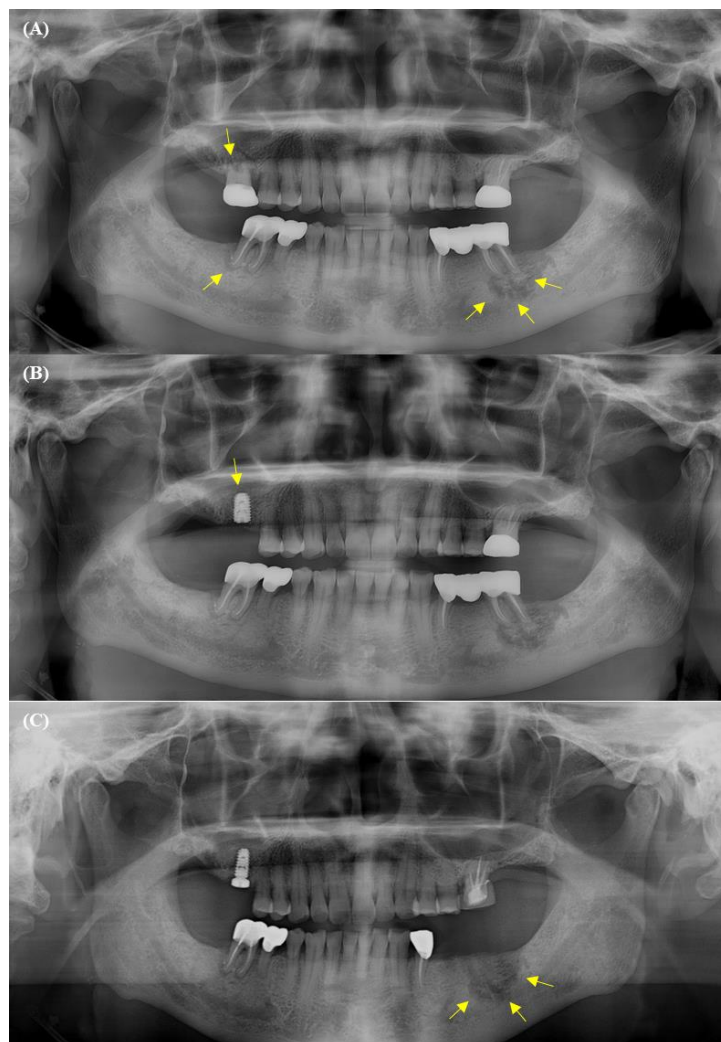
MRONJ case 2; (A) Panoramic radiograph taken at the initial visit, showing periodontitis in the right posterior maxillary region and MRONJ lesions in the right posterior maxilla, left posterior mandible, and right posterior mandible. (B) Panoramic radiograph following first-stage implant surgery in the right posterior maxillary region. (C) Panoramic radiograph following sequestrectomy in the left posterior mandibular region. Yellow arrows indicate areas of MRONJ lesions.
